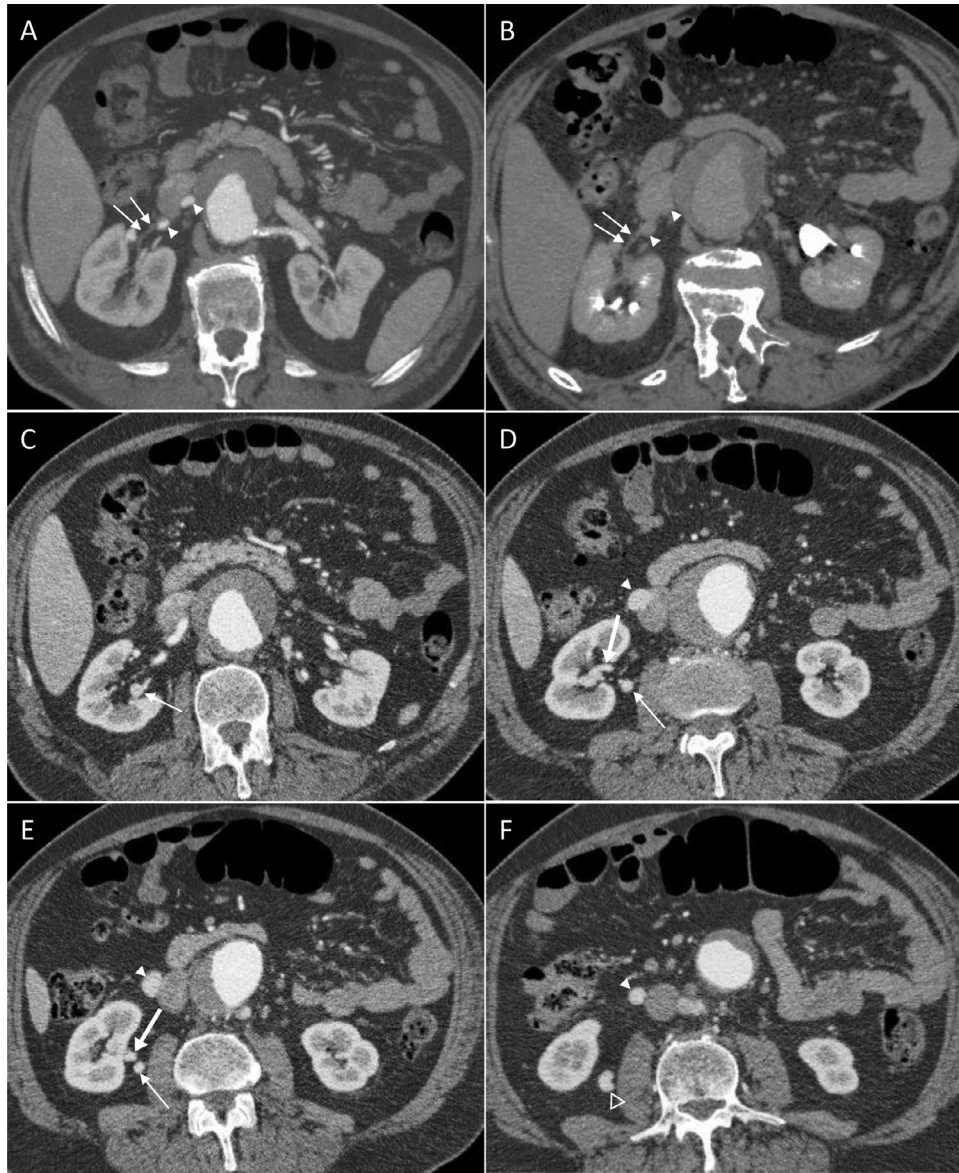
CT scanning. (A) Angiographic phase, axial MIP reconstruction. (B) Urographic phase, axial image at the same level of (A). (C-F) Angiographic phase, craniocaudal subsequent axial slices. A tiny vein (A and B: arrows) with mild contrast enhancement goes from right kidney hilum to inferior vena cava. Right renal artery is discontinuously recognizable (A and B: arrowheads). Two distinct branches (C-E: thick and thin arrows, respectively)—coming from kidney hilum—join to form 1 renal vein (F: empty arrowhead), located behind gonadal vein (D-F: full arrowhead); confluence of gonadal vein into inferior vena cava (C).
